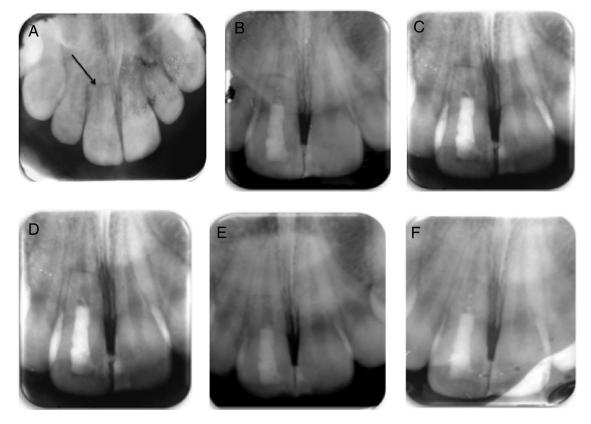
(*A*) Preoperative periapical radiograph of tooth #8 in case 1. The root is completely formed. A midroot horizontal fracture (*arrow*) is evident. (*B*) Postoperative periapical radiograph after completion of REPs. (*C*) Postoperative periapical radiograph at the 5-month follow-up. Fracture line still visible. No radiolucent lesion developed at the fracture line. (*D*) Postoperative periapical radiograph at the 8-month follow-up. The radiographic appearance is similar to that at the 5-month follow-up. (*E*) Postoperative periapical radiograph at the 14-month follow-up. Progressive healing of the horizontal root fracture by formation of hard tissue between fragments. (*F*) Postoperative periapical radiograph at the 19-month follow-up. Further healing of horizontal root fracture by formation of hard tissue.
